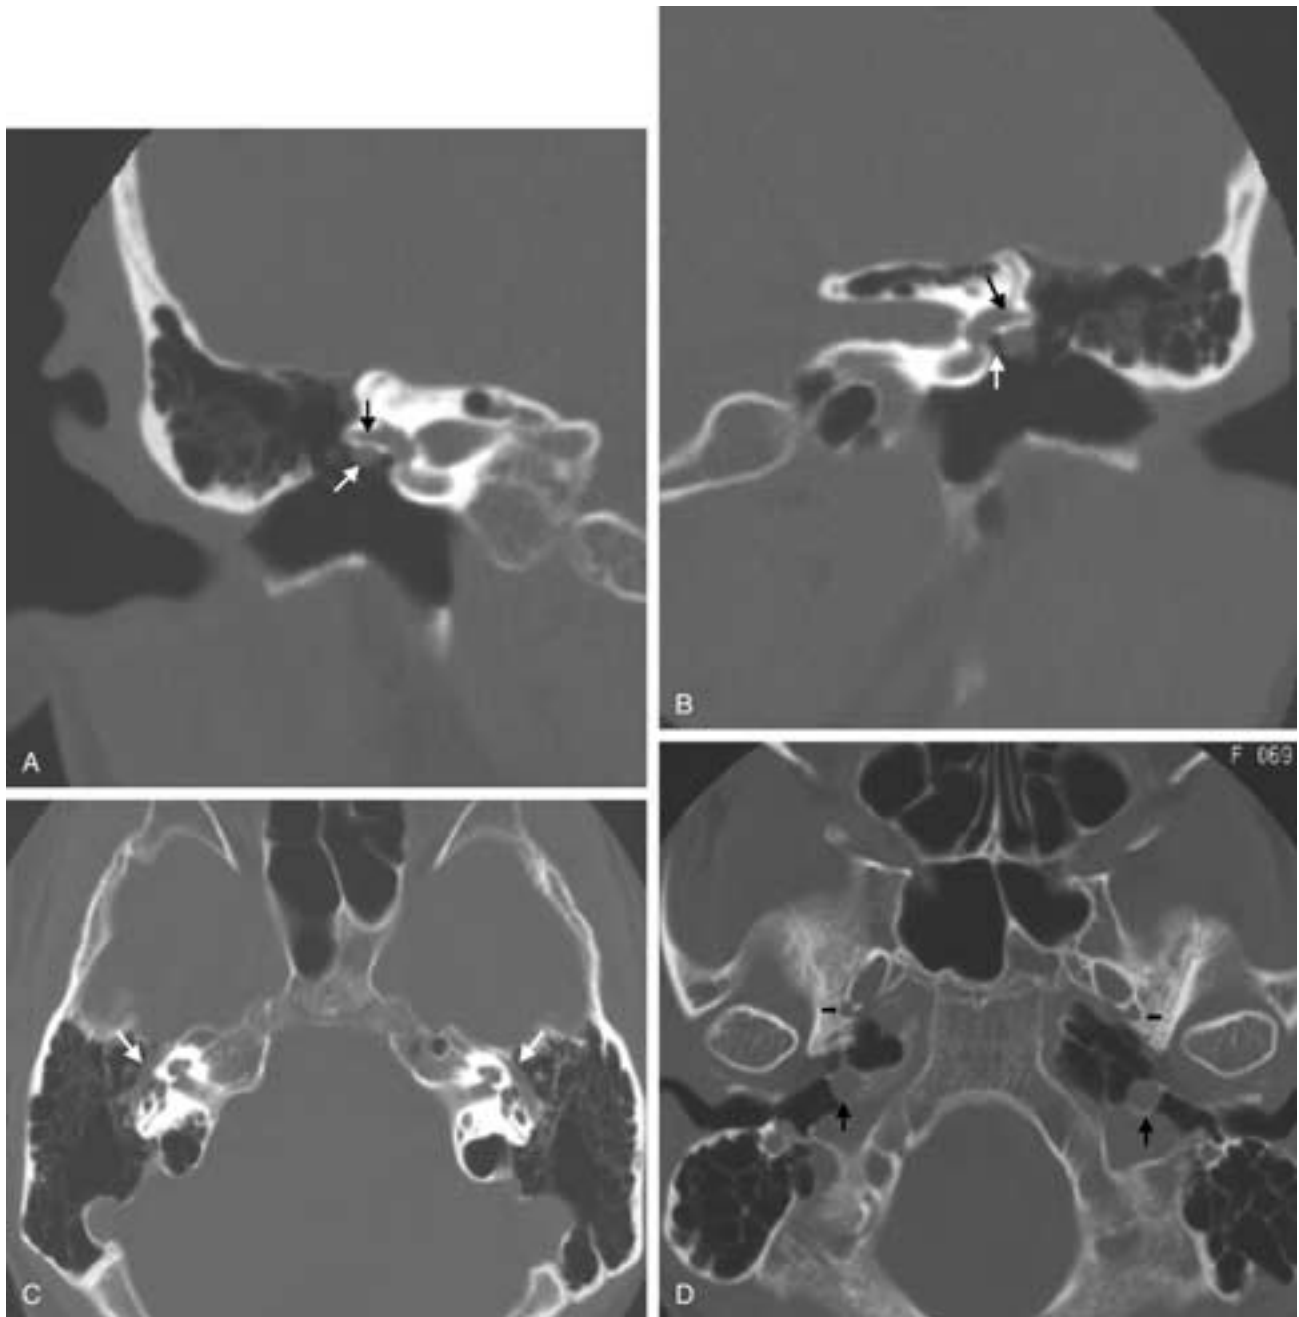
Dehiscent facial nerve. A and B, Right and left coronal CT images showing soft-tissue prominence in the middle ear cavity immediately inferior to the lateral semicircular canal (*black arrows*) in the expected location of the tympanic segment of the facial nerve (*white arrows*). No bony canal for tympanic segments consistent with dehiscence is identified. C, Axial CT image showing bilateral facial nerve dehiscence (*white arrows*). D, Axial CT image showing normal carotid canals (*long black arrows*) and presence of the foramen spinosum (*short black arrows*), indicating that the prominent soft tissue at the expected location of the tympanic facial nerve is not a persistent stapedial artery.
